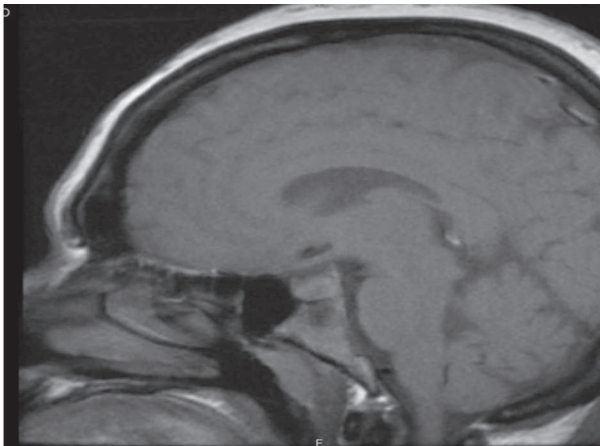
(A): MRI Pituitary (Sagittal View) Revealing Left Lobe 3mm Pituitary Microadenoma
